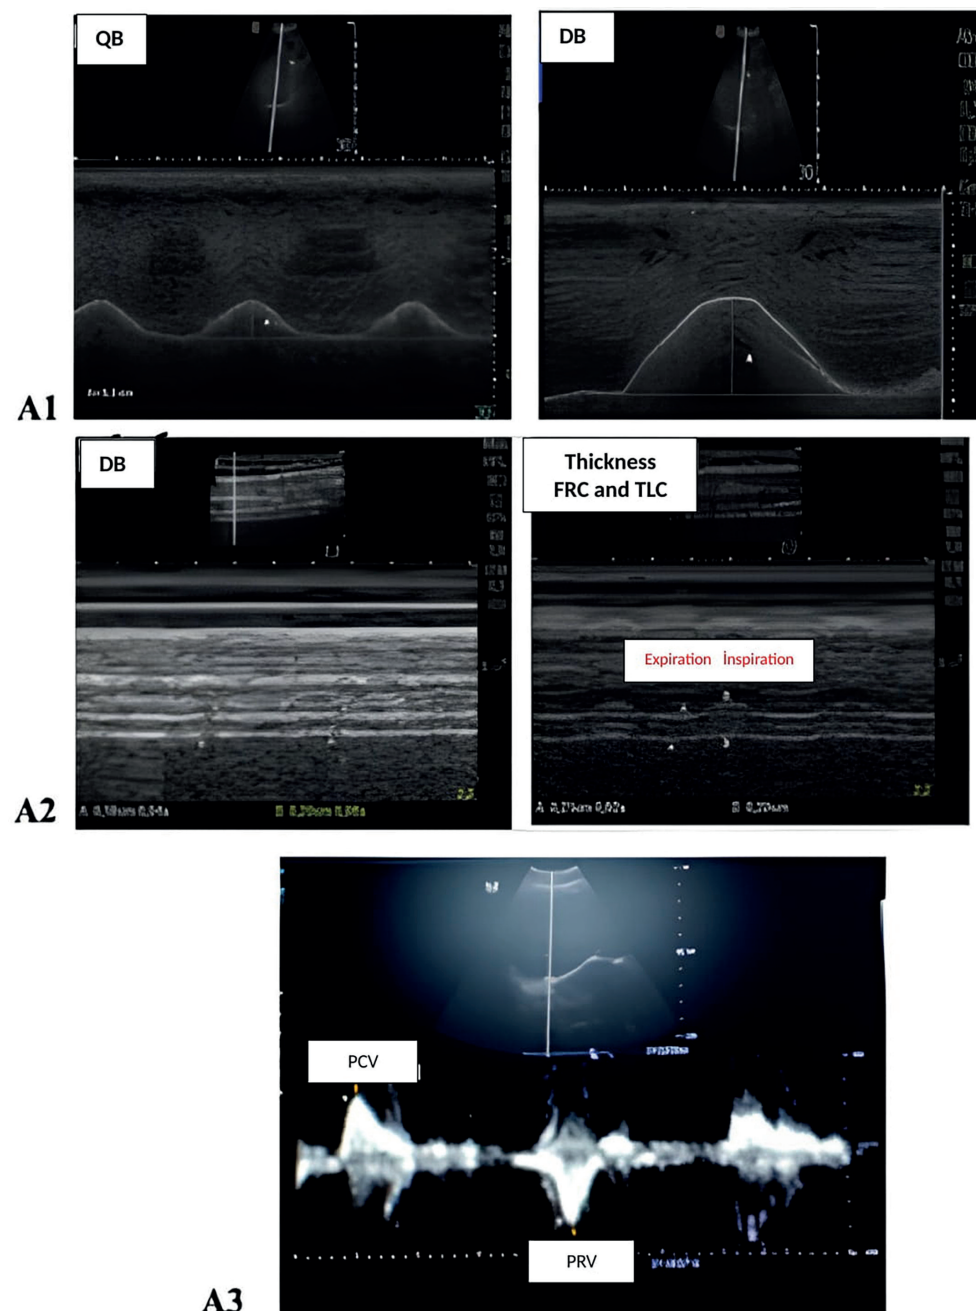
Panel of diaphragm ultrasound images
